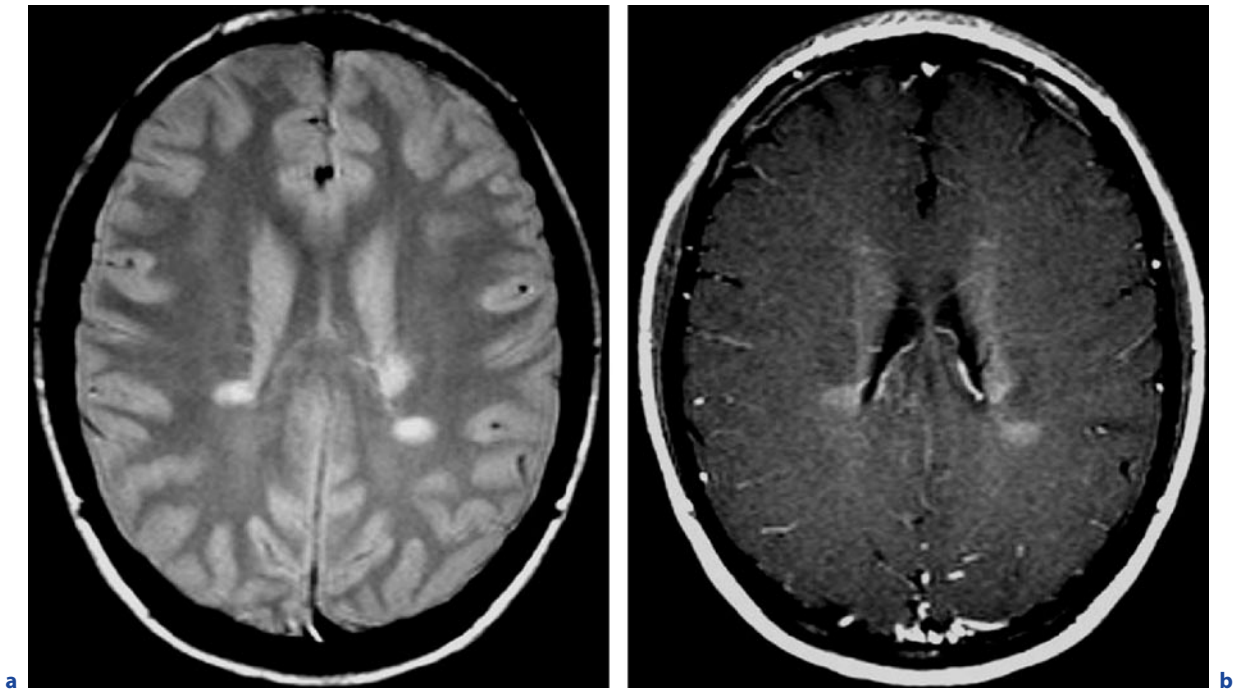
Dissemination time (II). a Axial PD-weighted image 3 months after optic nerve neuritis. b Axial T1-weighted image after contrast administration, same position as in a. T2 lesions (a) with contrast enhancement (b). Since these lesions
